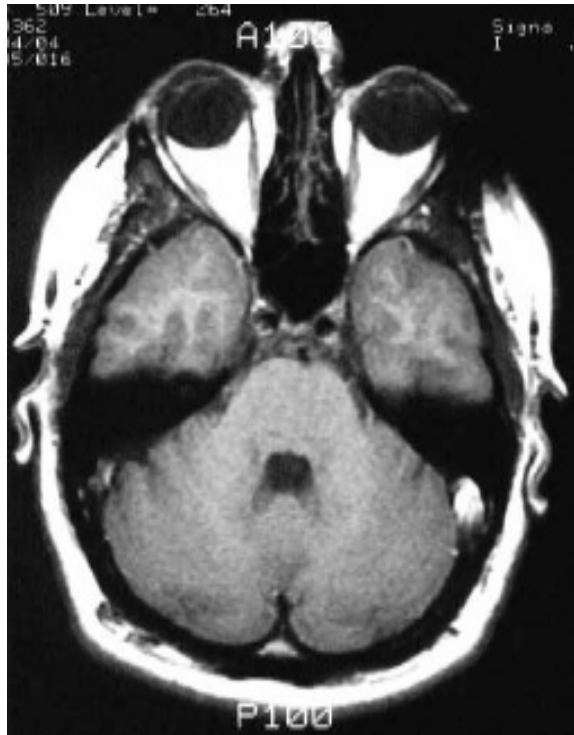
Axial MRI (T1) through the cerebellum. (From R, Swenson, Dartmouth Medical School)
